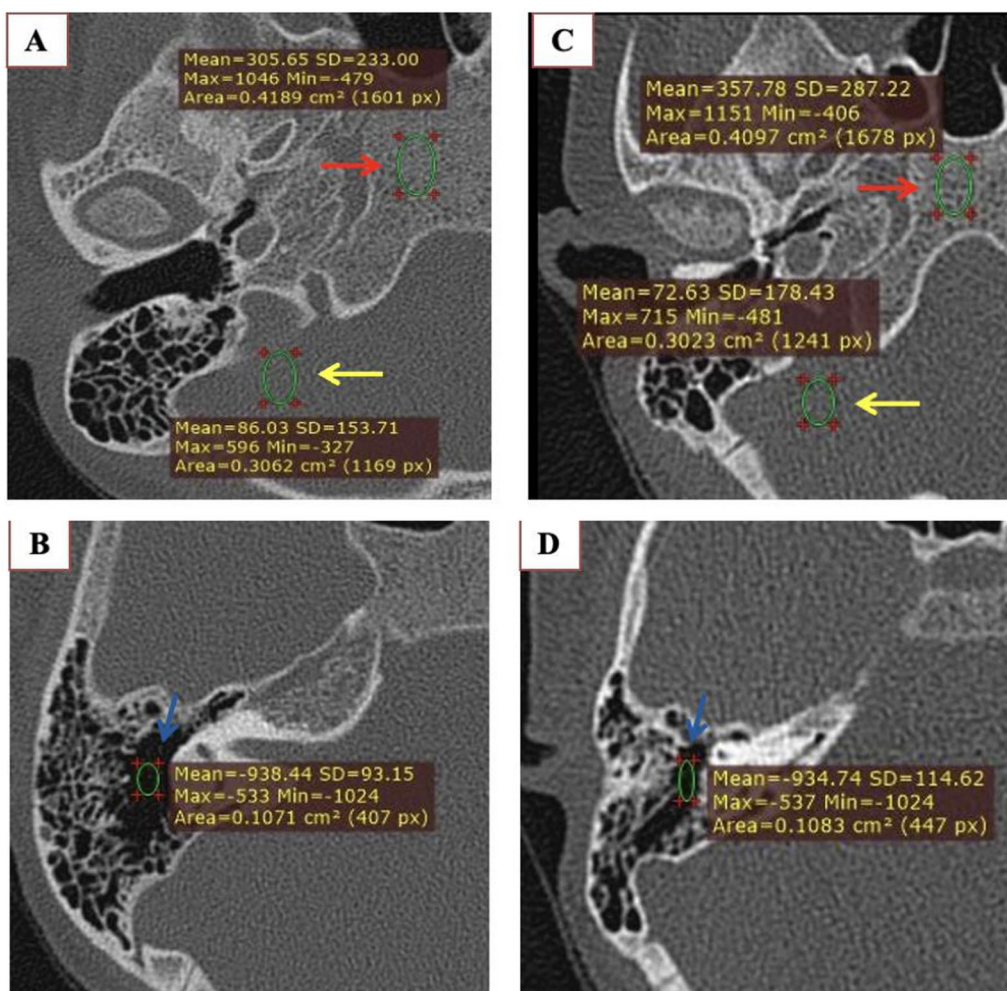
Image noise assessment on axial SDCT A, B in a 13-year-old girl and axial LDCT C, D in a 12-year-old girl. Region of interest measurements was done within soft tissue (yellow arrow), bone (red arrow) and air (blue arrow) for assessing image noise (SD). SDCT: 153 for soft tissue, 233 for bone and 93 for air. LDCT: 178 for soft tissue, 287 for bone and 114 for air. Image noise was higher in low-dose compared to standard-dose CT
